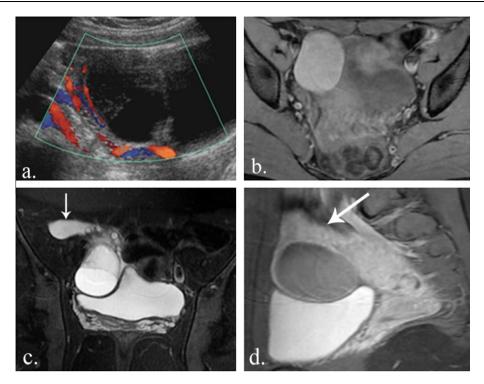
Leaking hemorrhagic ovarian cyst: a 23 year old female patient presented with right sided pelvic pain. (a) Transabdominal pelvic ultrasound of a hemorrhagic cyst shows the characteristic mesh of fine linear echoes referred to as a "lacy" or "fish net" appearance. Color Doppler shows perilesional flow with absence of blood flow in the fine septations, however the ovarian stroma was stretched by virtue of the described cyst such that intra ovarian blood flow could not be elicited, so the possibility of ovarian torsion was raised and MRI was recommended. (b) Axial T1 weighted image with fat saturation revealed a right ovarian cystic lesion displaying hyperintense signal denoting its hemorrhagic nature. (c) Axial T2 fat sat. image revealed hyperintense signal intensity of the right ovarian cyst with slight fluid leveling with adjacent mild amount of free fluid (arrow). (d) Sagittal contrast enhanced fat sat T1 weighted image revealed homogenously enhancing ovarian parenchyma (arrow) that is seen stretched by virtue of the described cyst.
